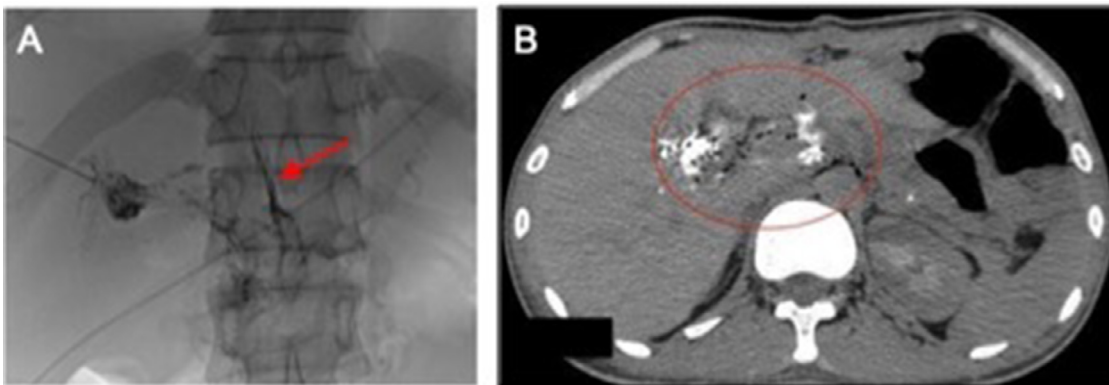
Case 3 Panel A: Transhepatic lymphangiography showing extravasation of contrast into the abdomen (arrow). Panel B: Conbeam CT was done after injecting foam, showing presence of air bubbles in lymphatic vessels at the hepatic hilum and lymphatic vessels retroperitoneal due to reflux (in the circle).
